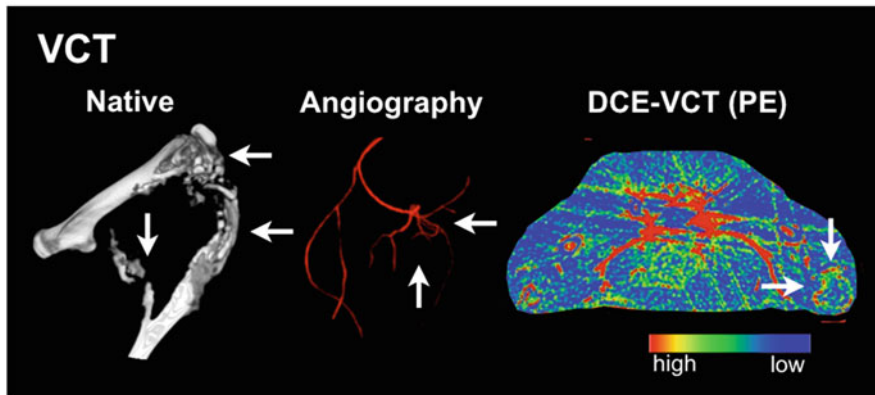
3D CT reconstructions of the osteolytic bone metastasis (*left panel*) and an angiography (*middle panel*) as well as a DCE-CT section in axial orientation from the parameter peak enhancement (associated with blood volume, *right panel*). The color map for DCE-CT data ranges from *red* (high values) to *blue* (low values). *Arrows* point at bone metastasis. Figure reprinted with permission from [14]
